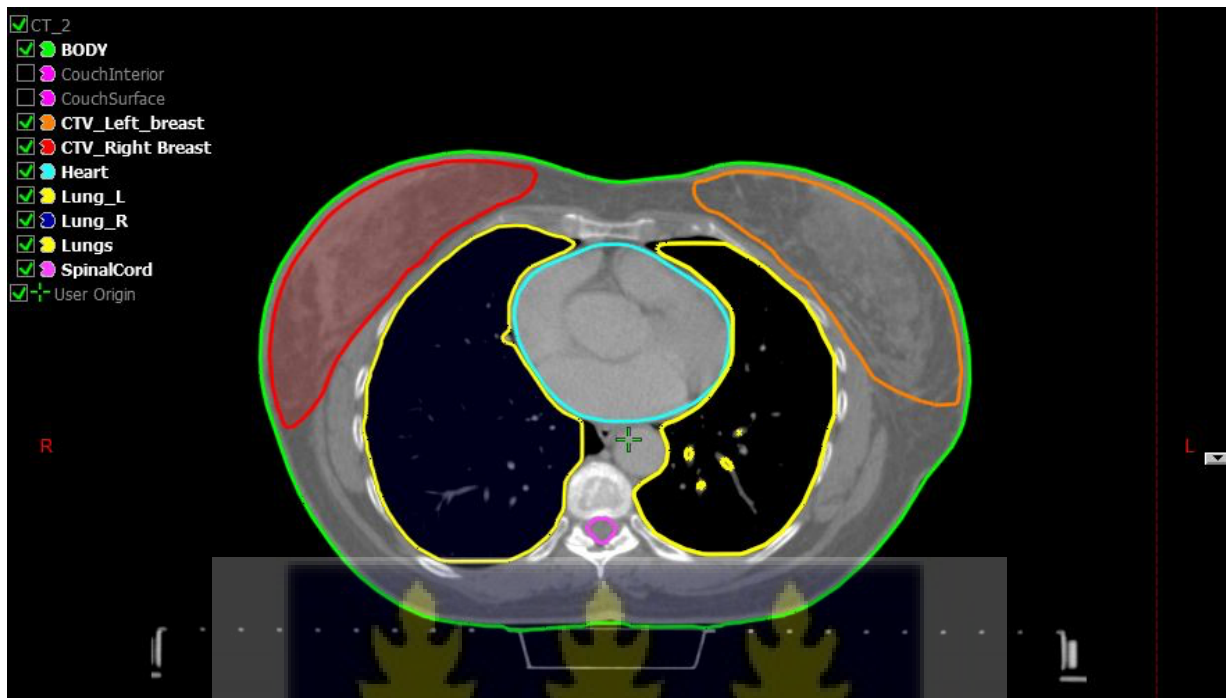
Transverse view of a CT image indicating the contoured organs at risk and CTV.
